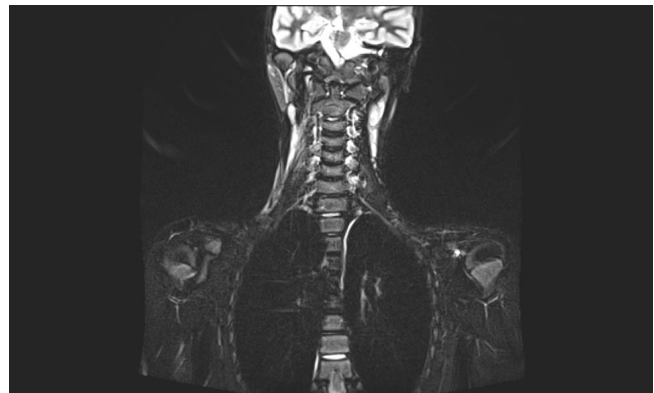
Cervical magnetic resonance imaging of the patient. Edema between the subcutaneous muscle plans on the right side of the neck and the root of the C₆ nerve.
